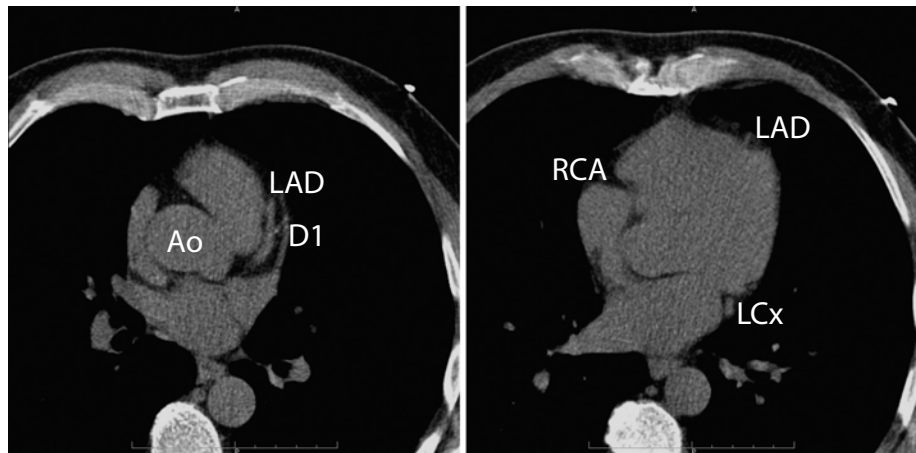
Unenhanced coronary scan with 4-slice CT in an individual without detectable calcification. The coronary arteries are well seen in the epimyocardial course. Ao Aorta, LAD left anterior descending artery, D1 first diagonal branch, LCx left circumflex coronary artery, RCA right coronary artery
